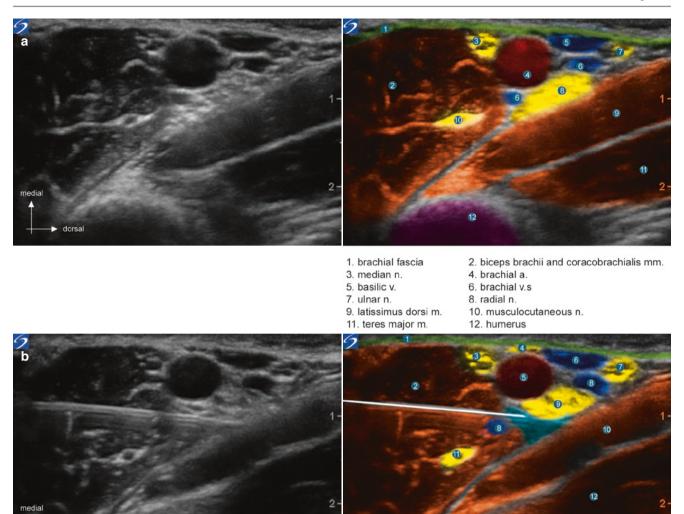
Ultrasound-guided axillary block. Position of probe. Needle inserted in-plane
